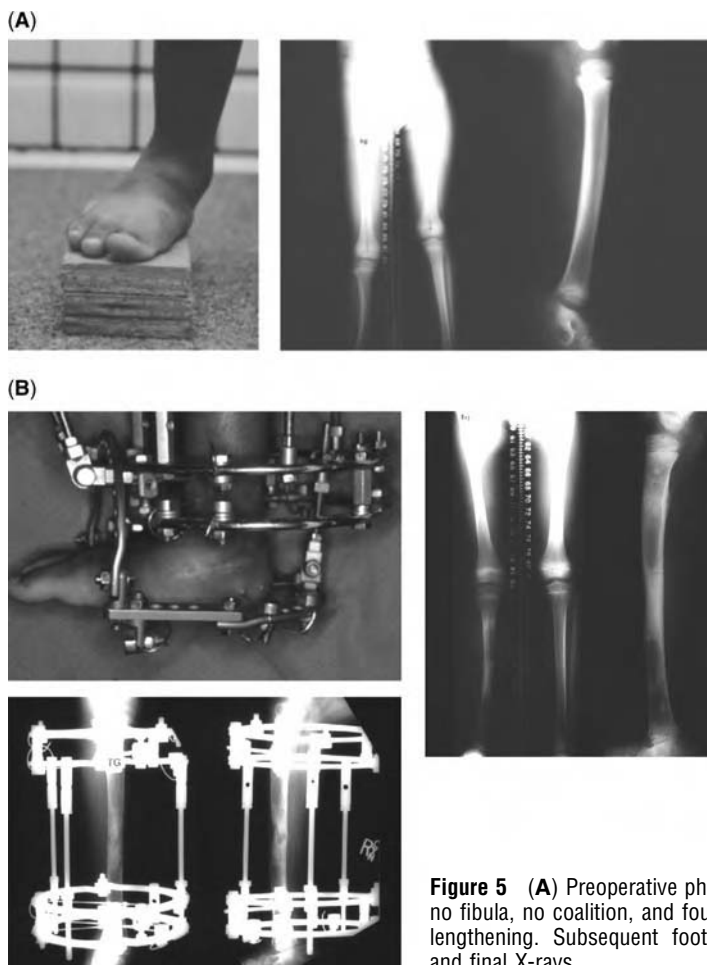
(A) Preoperative photo and long radiograph of patient with no fibula, no coalition, and four toes. (B) Photo in foot frame during lengthening. Subsequent foot frame removal during consolidation and final X-rays.
